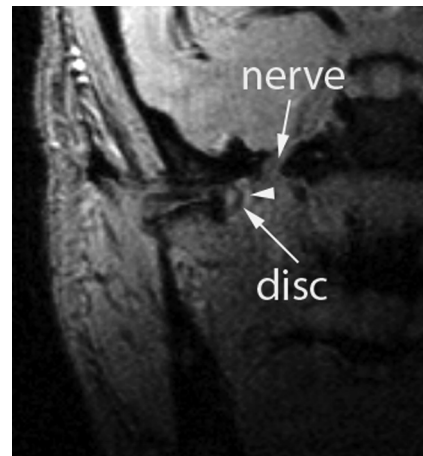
Paracoronal MR image of the TMJ at the maximal open-mouth position in a patient with TMJ-D and neuropathic pain. The reduced distance between the medially displaced disc and the oval foramen-mandibular nerve is well demonstrated. Note also the simultaneous presence of joint effusion (arrowhead).
